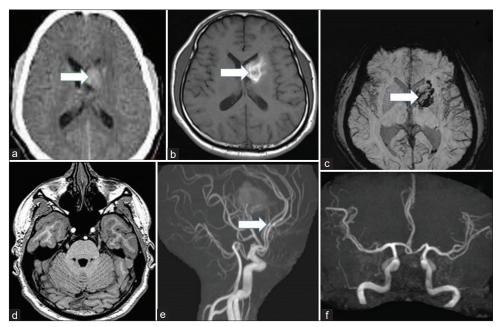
(a) Computed tomography showing hematoma in left caudate nucleus with intraventricular extension. (b and c) magnetic resonance imaging (MRI) showed subacute hematoma in left caudate nucleus. (d) T2 FLAIR image showing bilateral normal abducens nuclei. (e) MR Angiogram showing constriction in bilateral anterior cerebral arteries. (f) Normal MR Angiogram of intracranial vessels at 4 weeks of follow-up
